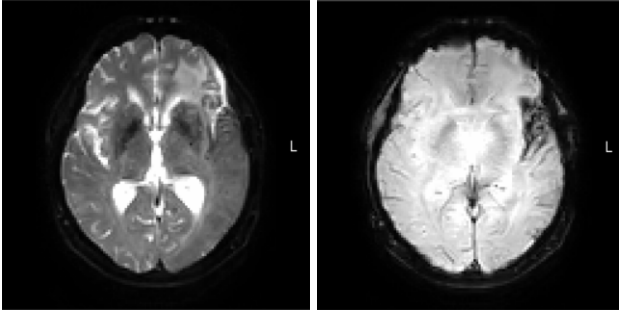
left: SE-EPI, right: GE-EPI. Both are MR images of the same tumor patient.
